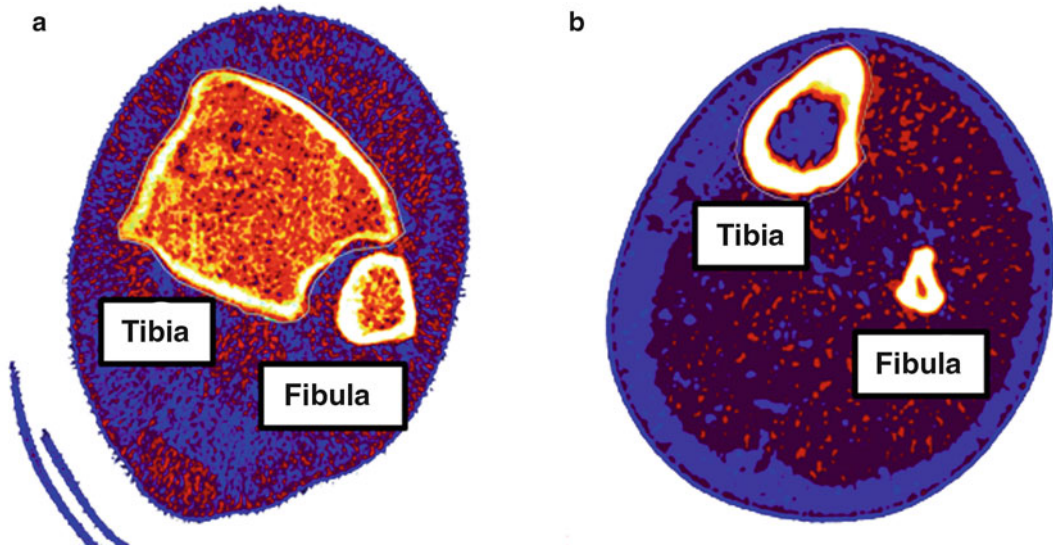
A peripheral quantitative computed tomography (pQCT) image of the tibia. (a) A pQCT image of the epiphyseal site of the tibia (mostly trabecular bone). The white area represents the cortical bone shell. (b) A pQCT image of the diaphyseal site of the tibia (mostly cortical bone)
